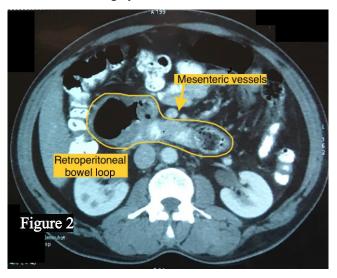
CT images show the bowel loop arising form sigmoid colon
